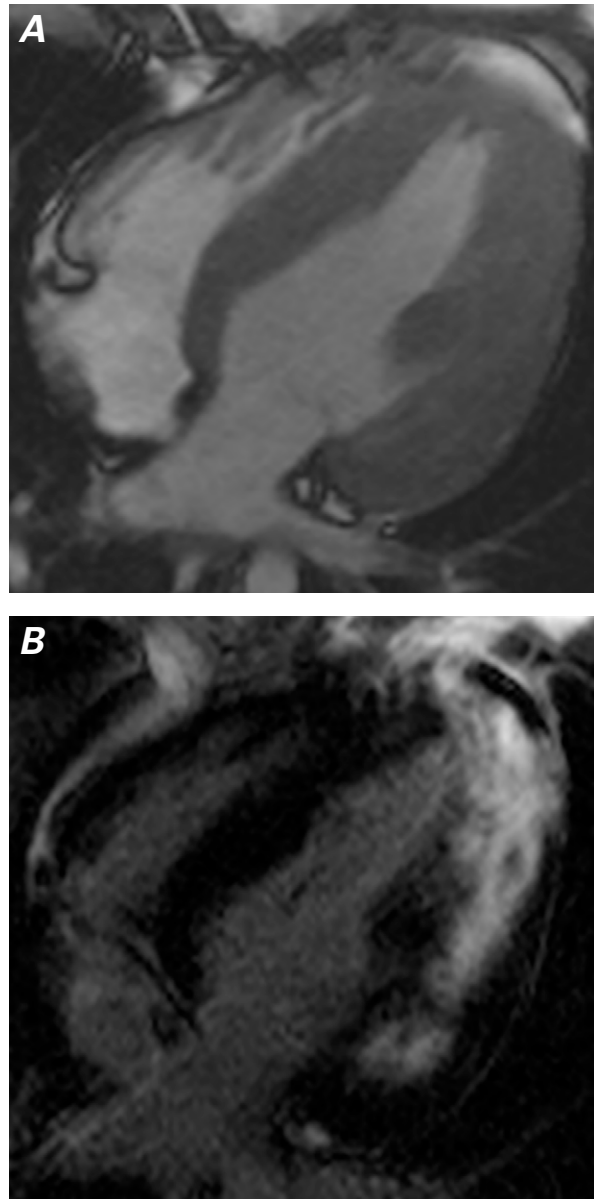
A) Cardiac magnetic resonance image with horizontal long-axis steady-state free-precession. B) Inversion recovery image obtained 10 minutes after the administration of gadolinium-based contrast medium. These images show left ventricular hypertrophy and extensive late gadolinium enhancement throughout the lateral wall and apex.
